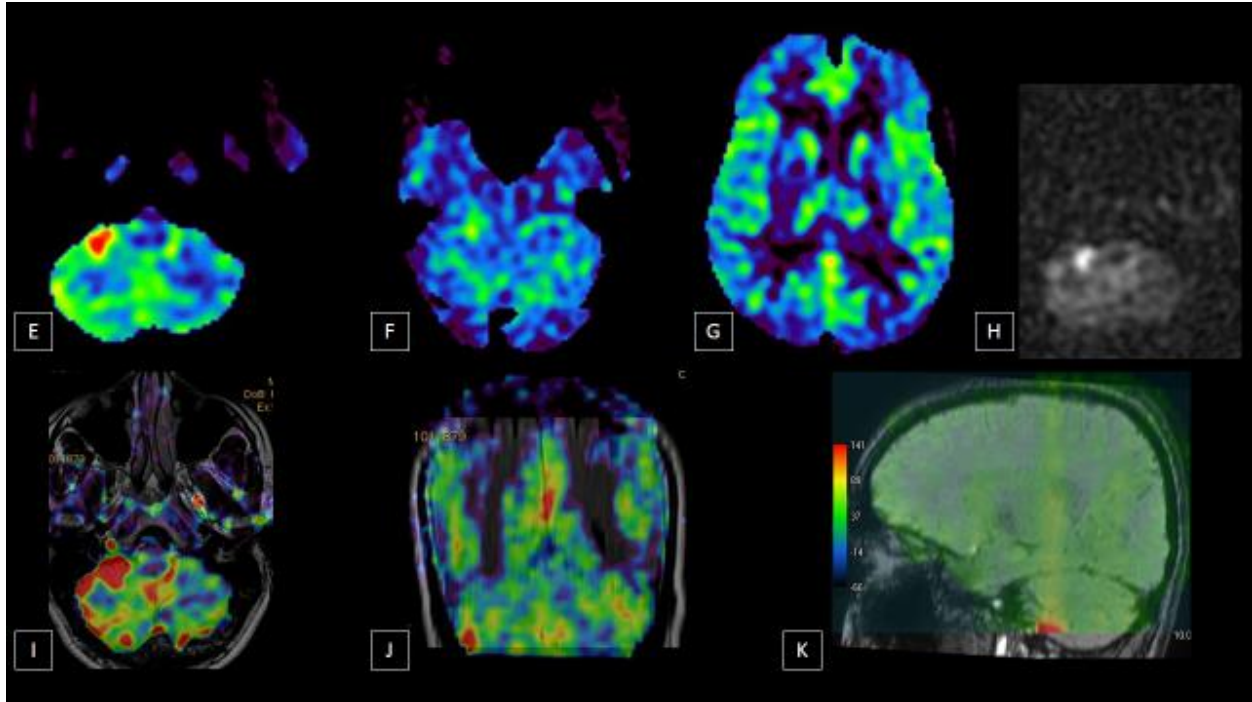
ASL Images. (E) (H) Bright signal within right sigmoid sinus/jugular fossa region (F) No abnormal signal in transverse sinus or torcula (G) No CVR (I), (J) and (K) ASL/FLAIR fusion multiplanar images showing site of fistula with no retrograde venous flow
